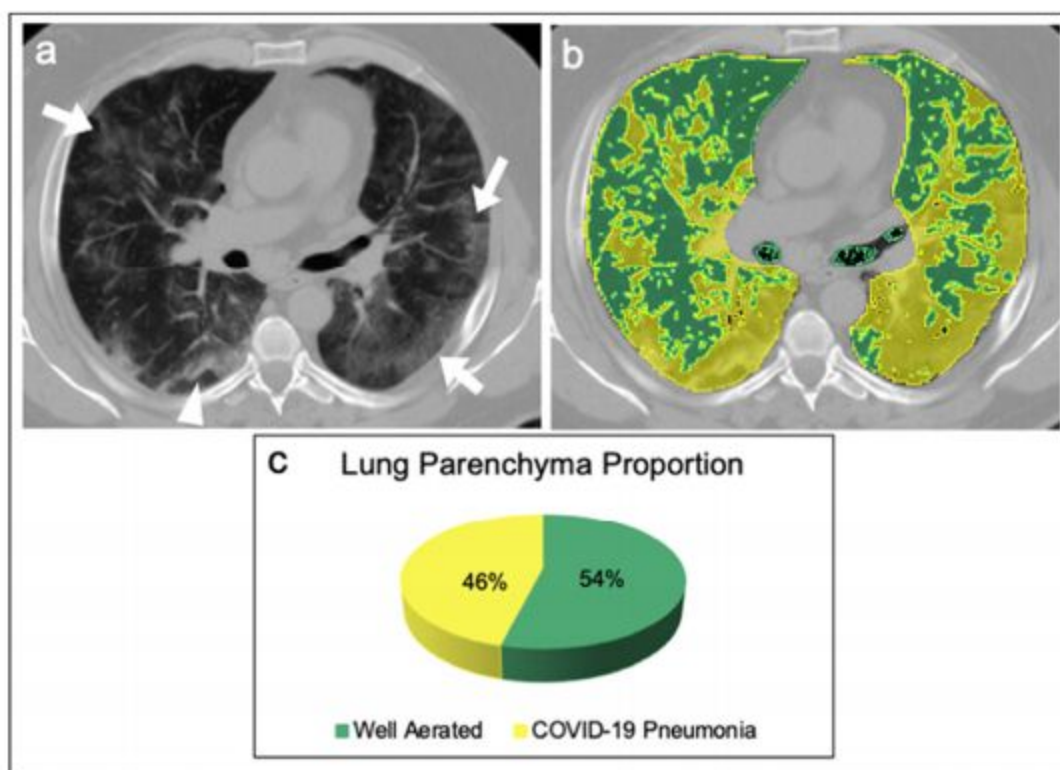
A 65 years old male affected by COVID-19 pneumonia admitted in ICU. (a) Nonenhanced axial chest CT image showed bilateral patchy ground glass opacities (arrows) with random distribution and peripheral band-like consolidation in the right lower lobe (arrowhead), with a visual quantification
